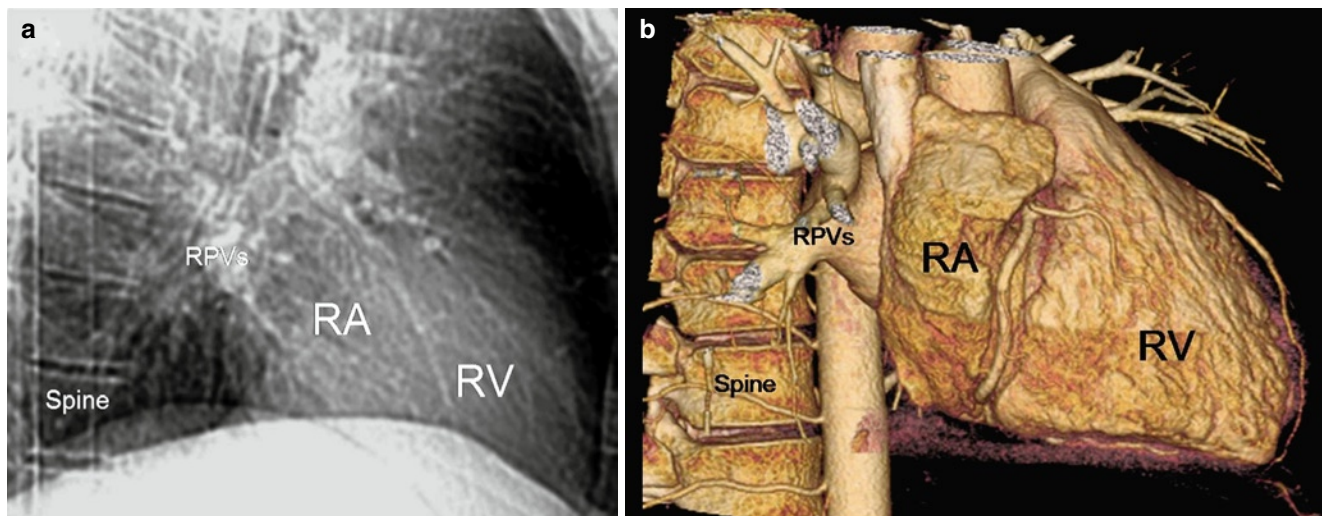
(a) Fluoroscopic image in right lateral projection and (b) the corresponding 3D CT volume rendering. RA Right atrium, RV right ventricle, RPVs right pulmonary veins
